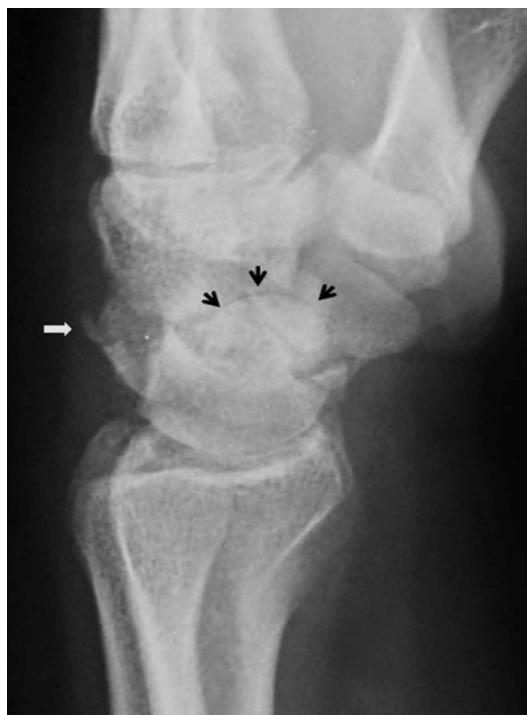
Lateral radiograph of the right wrist shows the domed articular surface of the proximal capitate fragment (black arrows) and an avulsion flake fracture of the dorsal surface of the triquetrum (white arrow). The capitate fragment is rotated 180° facing distally and is displaced palmarly between the lunate and the distal capitate fragment.
